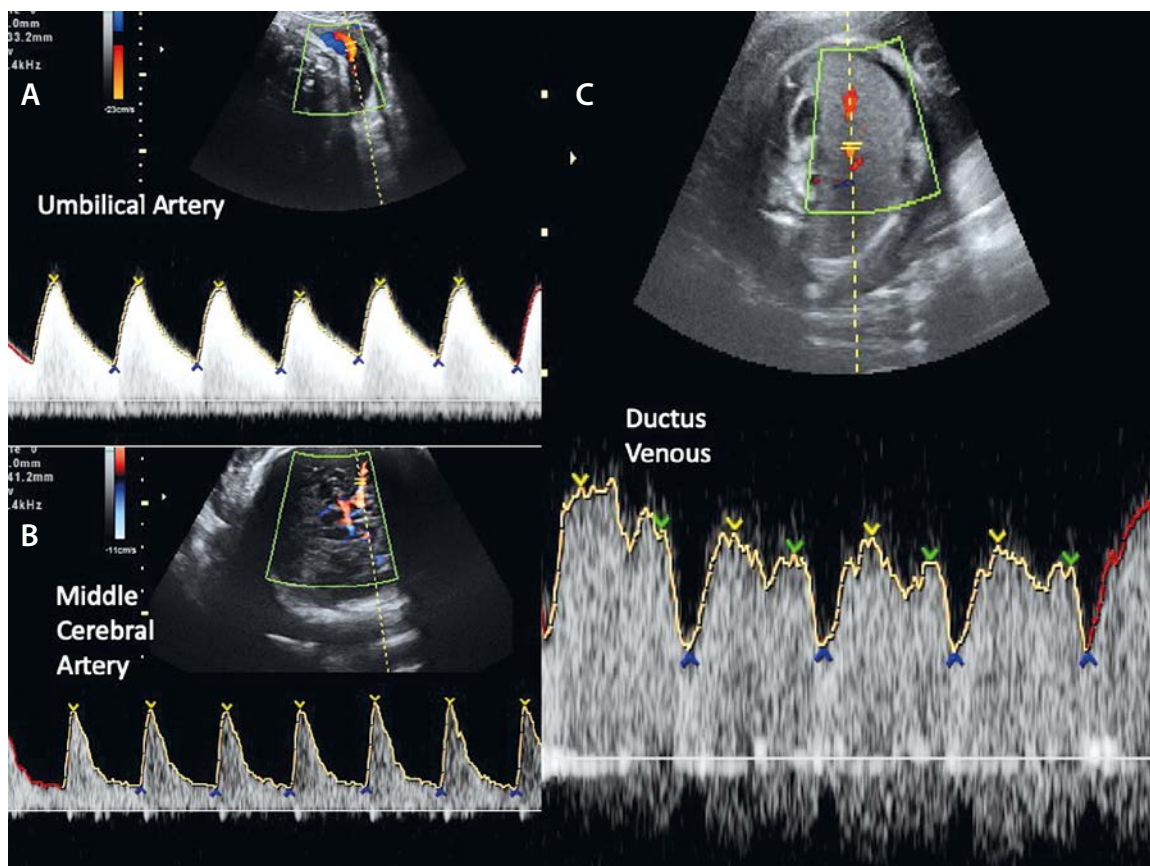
Fetal (A) umbilical Doppler, (B) middle cerebral artery, and (C) ductus venosus
